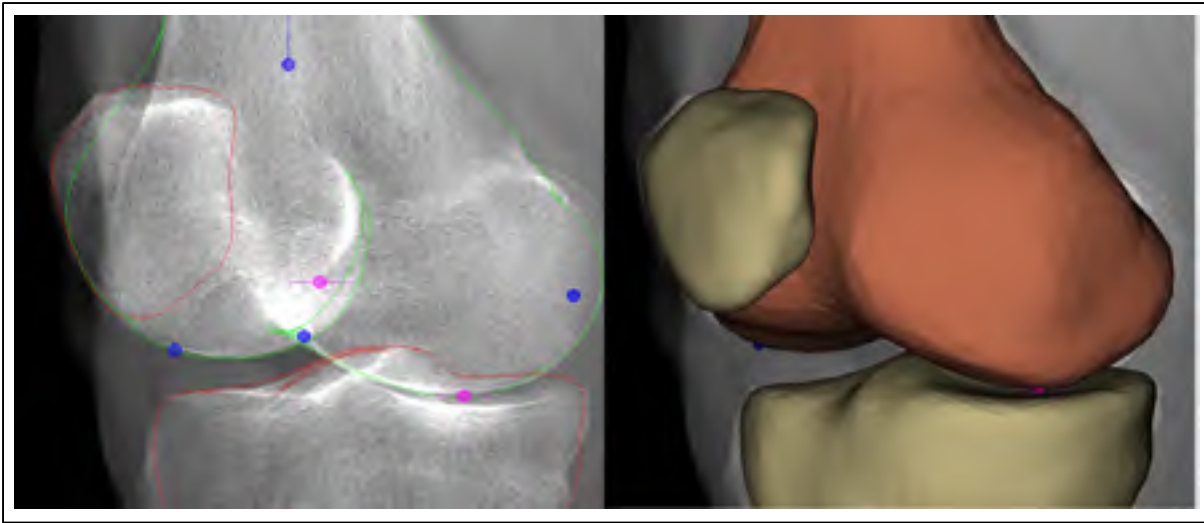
Reconstruction of the bone using EOS® biplane X-ray images.
